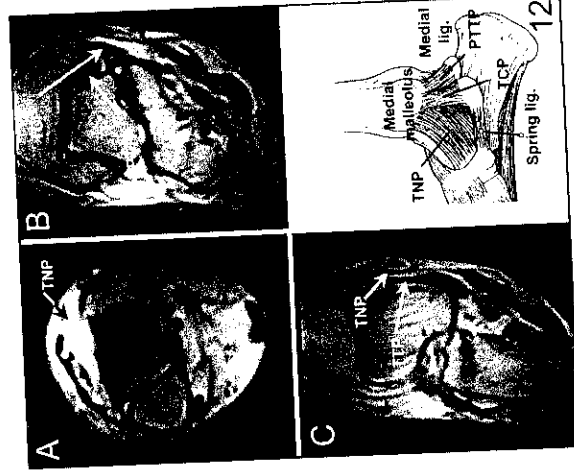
Picture and MRI scan image (A, B, C) of the medial ligament. A: On the surface, tibionavicular part (TNP); B: Tibio calcaneal part (TCP) and posterior tibiotalar part (PTTP); C: Anterior tibiotalar part (ATTTP) which is located underneath the tibionavicular part (TNP).
